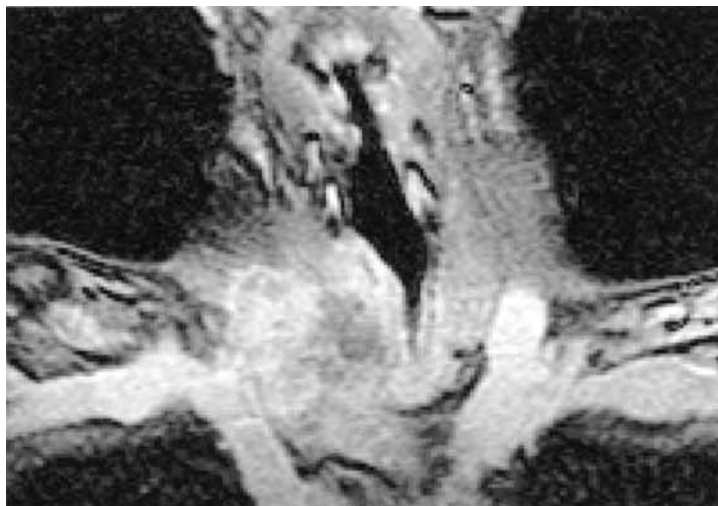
Coronal contrast-enhanced MRI shows that the tracheal lumen is narrowed due to a locally elevated tracheal wall. The endotracheal surface is smooth.
